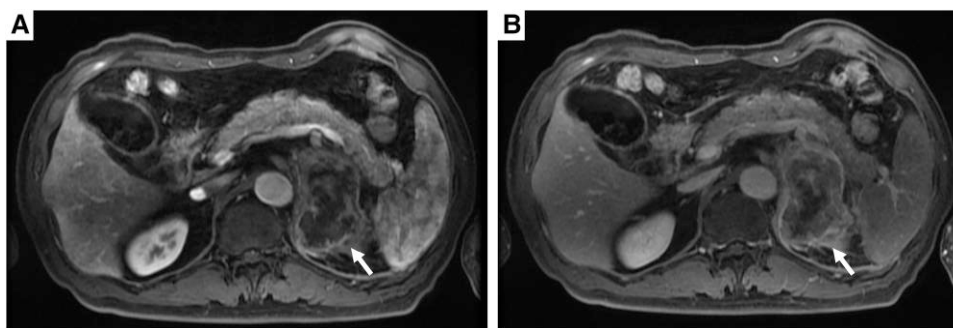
Contrast-enhanced magnetic resonance imaging. (A) Early phase; (B) late phase.
